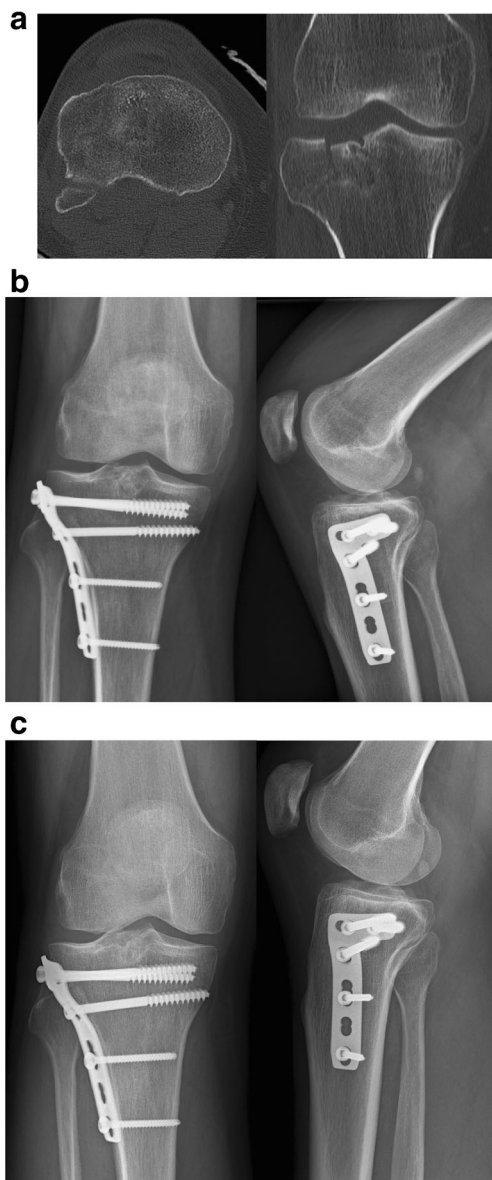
Demonstrative case with good functional outcome. a Pre-operative CT-images showing a lateral column fracture with a depressed central fragment. b Post-operative coronal and sagittal X-rays after anterolateral plating. c Coronal and sagittal X-rays at 2 years follow-up
